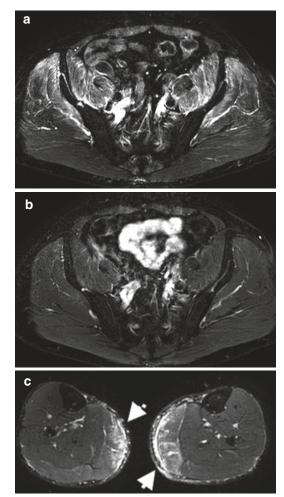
A 53-year-old male presenting with proximal muscle weakness over the lower extremity with biopsy-proven idiopathic polymyositis. (a) Axial T2FS MRI proximal pelvis demonstrates bilateral extensive myositis, high signal intensity (*arrows*) with (b) full response to treatment. (c) Axial MRI bilateral calves in a 62-year-old male with dermatomyositis demonstrating bilateral myositis medial gastrocnemius and subcutaneous edema
